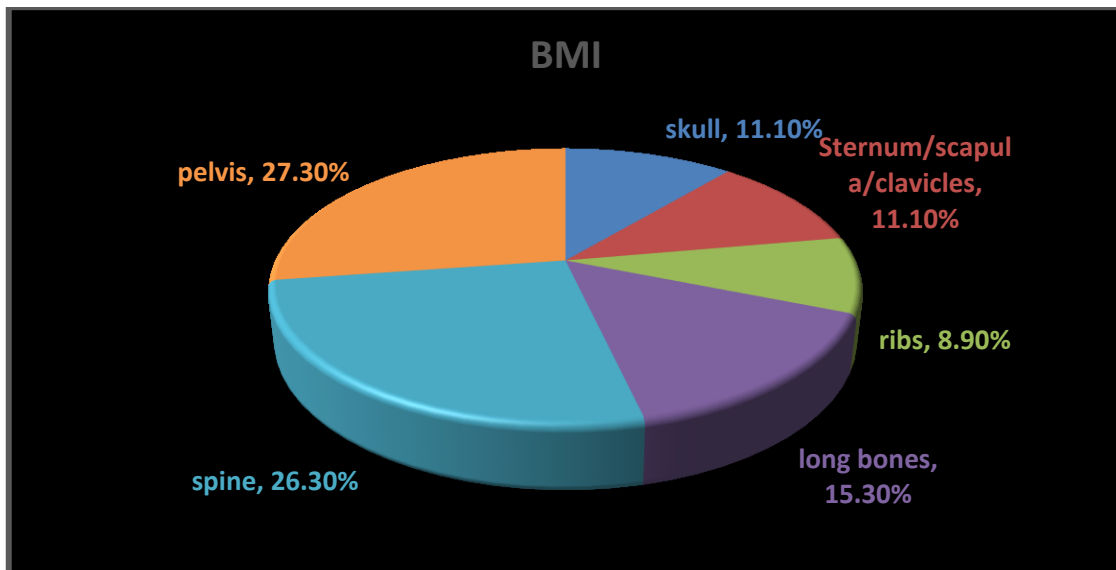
Regional distribution of bone infiltration in different skeletal sites using PET/CT (n. of sites = 190).
